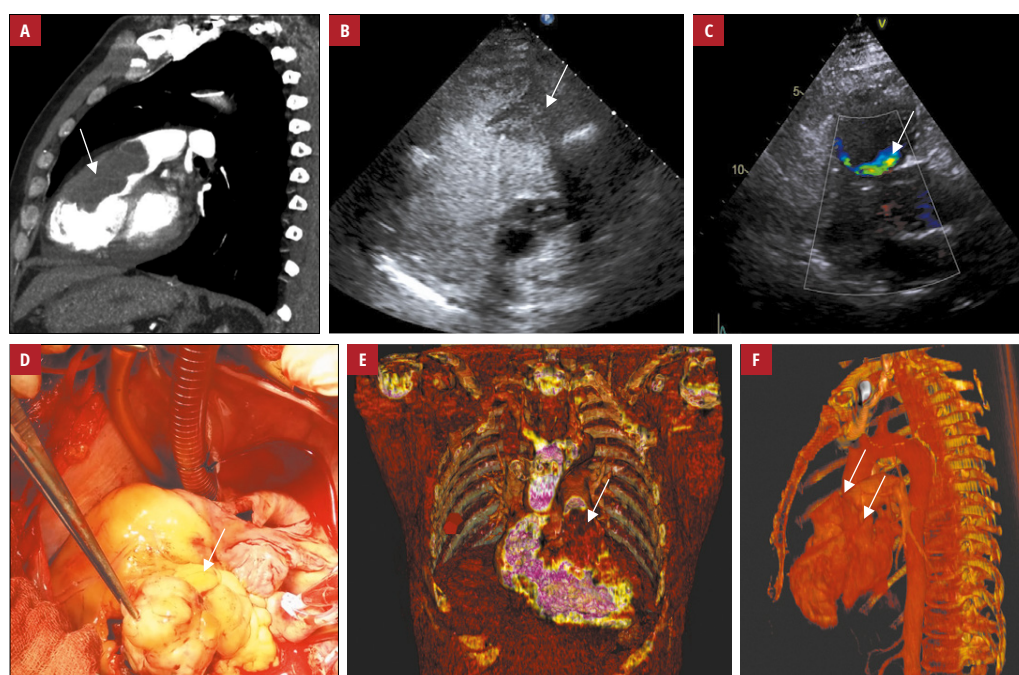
A – sagittal computed tomography scan showing a hypodense neoplasm filling the pulmonary trunk and the right ventricular outflow tract (arrow); B – contrast transthoracic echocardiography showing the negative contrast effect in the right ventricular outflow tract (arrow); C – color Doppler echocardiography showing residual blood flow in the right ventricle (white arrow); D – photography done during the surgery showing the excised tumor (white arrow); E – 3D visualization (Vesalius3D, PS-Medtech, Amsterdam, the Netherlands) from computed tomography scans without contrast showing neoplasm filling the pulmonary trunk and the right ventricular outflow tract (arrow); F – 3D visualization (Vesalius3D) from computed tomography scans with contrast showing the residual blood flow (arrows) caused by the huge neoplasm filling almost the entire right ventricle.
